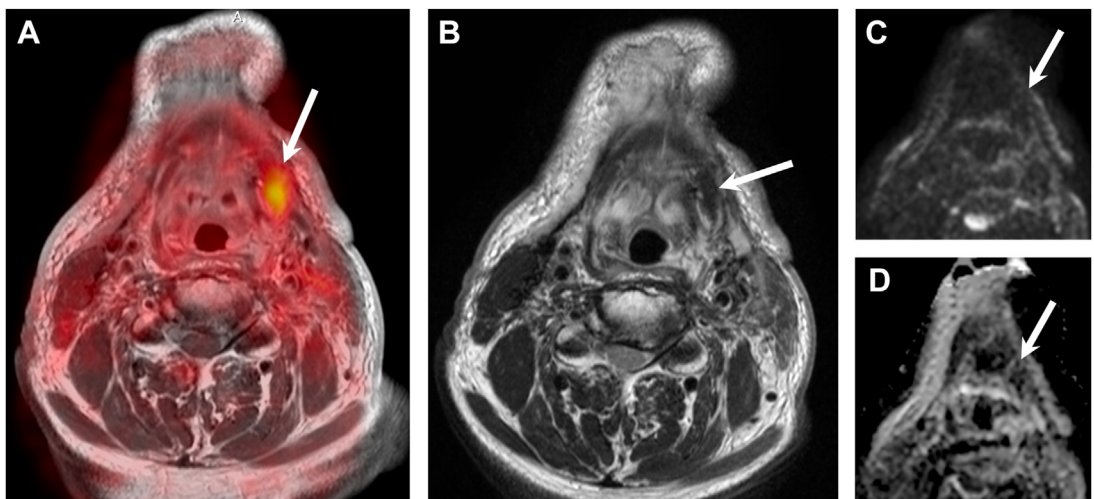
Posttreatment scar in a patient with radiotherapy, partial pelviglossectomy and left neck dissection for an SCC of the oral cavity. Images obtained from a PET/DWIMR imaging examination. (A) Fused PET with contrast-enhanced T1W image (arrow). (B) Corresponding T2W image. (C) b 1000 image. (D) ADC map. Note an area of focal uptake on the fused PET and contrast-enhanced T1W image. $SUV_{max} = 9$. The T2W image shows an area with very low signal intensity (arrow) corresponding to mature scar tissue. On DWI, a T2 black-out effect (arrows) is seen resulting in a low ADC value ($ADC = 0.93 \times 10^{-3} \text{ mm}^2/\text{s}$).
